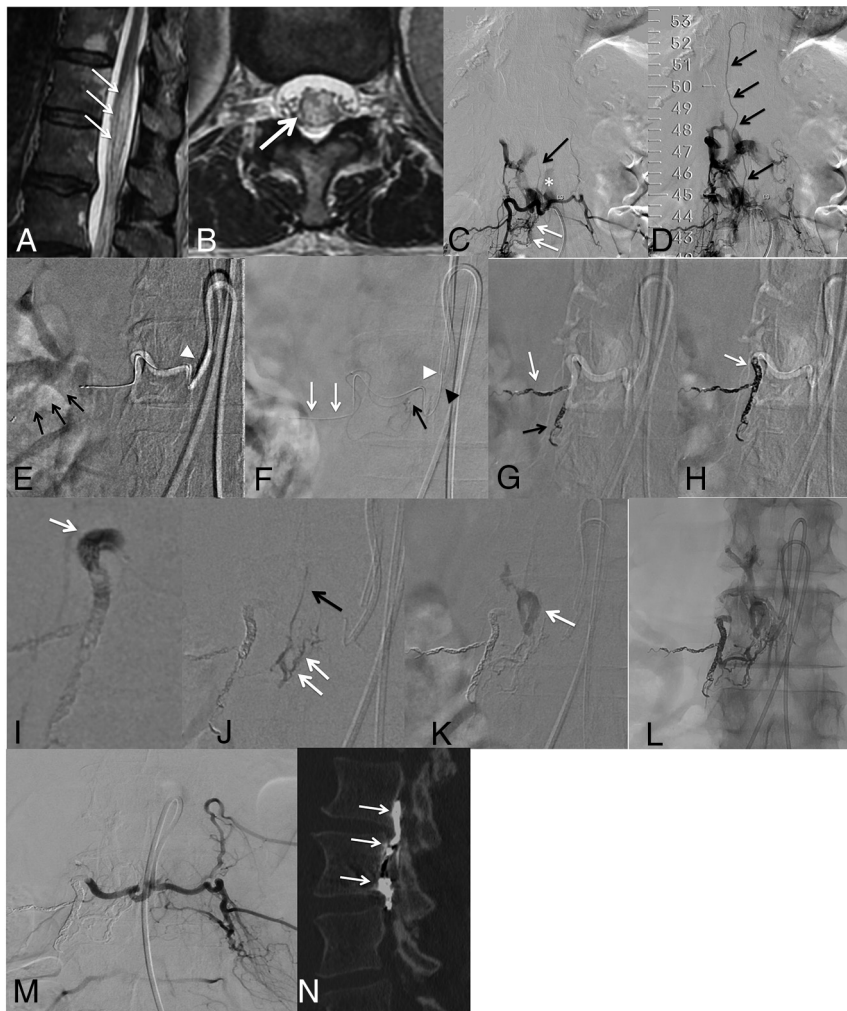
Patient in his or her 60's presenting with a 4-year history of paresthesia of the inferior limbs, bladder disturbance, and constipation. Spinal cord MR imaging. T2WI, sagittal (A) and axial (B) slices show a centromedullar hyperintense signal (white arrows) and lumbar spinal cord enlargement. Spinal DSA. Right L3 selective angiogram in a postero-anterior projection at an early phase (C) and intermediate phase (D). Numerous dural branches from the right L3 spinal trunk are depicted (C, white arrows), with abnormal connection with the right aspect of the epidural plexus (C, asterisk). Reflux from the anterior epidural plexus to a radicular vein is seen (C and D, black arrows), with an ascending drainage. E, Navigation of a 0.017-inch microcatheter via a 5F Simmons 1 catheter (white arrowhead). The microcatheter is stabilized by deploying a Catch Mini stent retriever (black arrows); then the guiding catheter is gently pulled away from the right L3 ostium. F, An Apollo (5-cm detachable tip) microcatheter is then navigated in the spinal trunk of the right L3 artery, as close as possible to the shunt point (black arrow). Selective DSA via the Apollo microcatheter in a postero-anterior projection. Note the guiding catheter (5F Simmons 1) at the ostium of the right L3 artery (black arrowhead), while the second one is stabilized in front of it (white arrowhead). Note the second 0.017-inch microcatheter that has been left in the main trunk of right L3 artery (white arrows). Coiling, via the 0.017-inch microcatheter, of the main L3 trunk (G, white arrow), then the dorso-spinal trunk (G, black arrow) and the arterial segment before arising from the dorso-spinal trunk (H, white arrow) to obtain the proximal plug of the pressure cooker. Finally, a 50% dilution *n*-BCA injection was performed at the proximal aspect of the cast of the coils through the 0.017-inch microcatheter (I, white arrow) to ensure that the proximal plug would be occlusive. Then, Squid 12 (Balt) was injected under a blank roadmap through the Apollo catheter until occlusion of the shunt point along the anterior epidural venous plexus (J and K, white arrows) and filling of the origin of the radicular vein (J, black arrow). L, Plain x-ray in a postero-anterior projection at the end of the Squid 12 injection shows the EVOH cast. M, Final control DSA in a postero-anterior projection via the common trunk feeding both the right and left L3 arteries, showing complete occlusion of the fistula. N, Postprocedural unenhanced CT scan, bone windowing. Sagittal reconstruction shows the EVOH cast in the anterior epidural venous plexus (white arrows).
